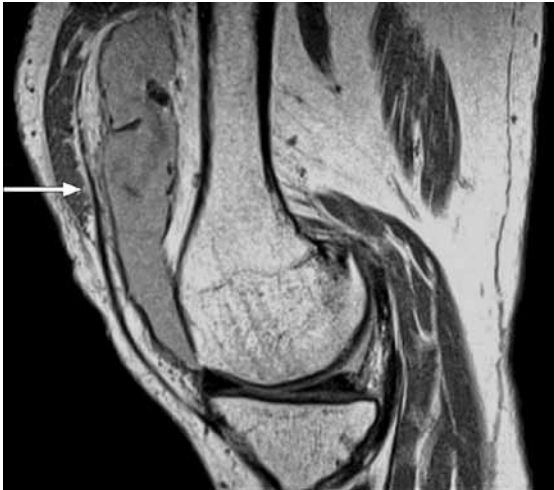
MR image of the right knee shows large joint effusion at the suprapatellar recess, demonstrating a fluid-fluid level (arrow) due to layering of blood.
